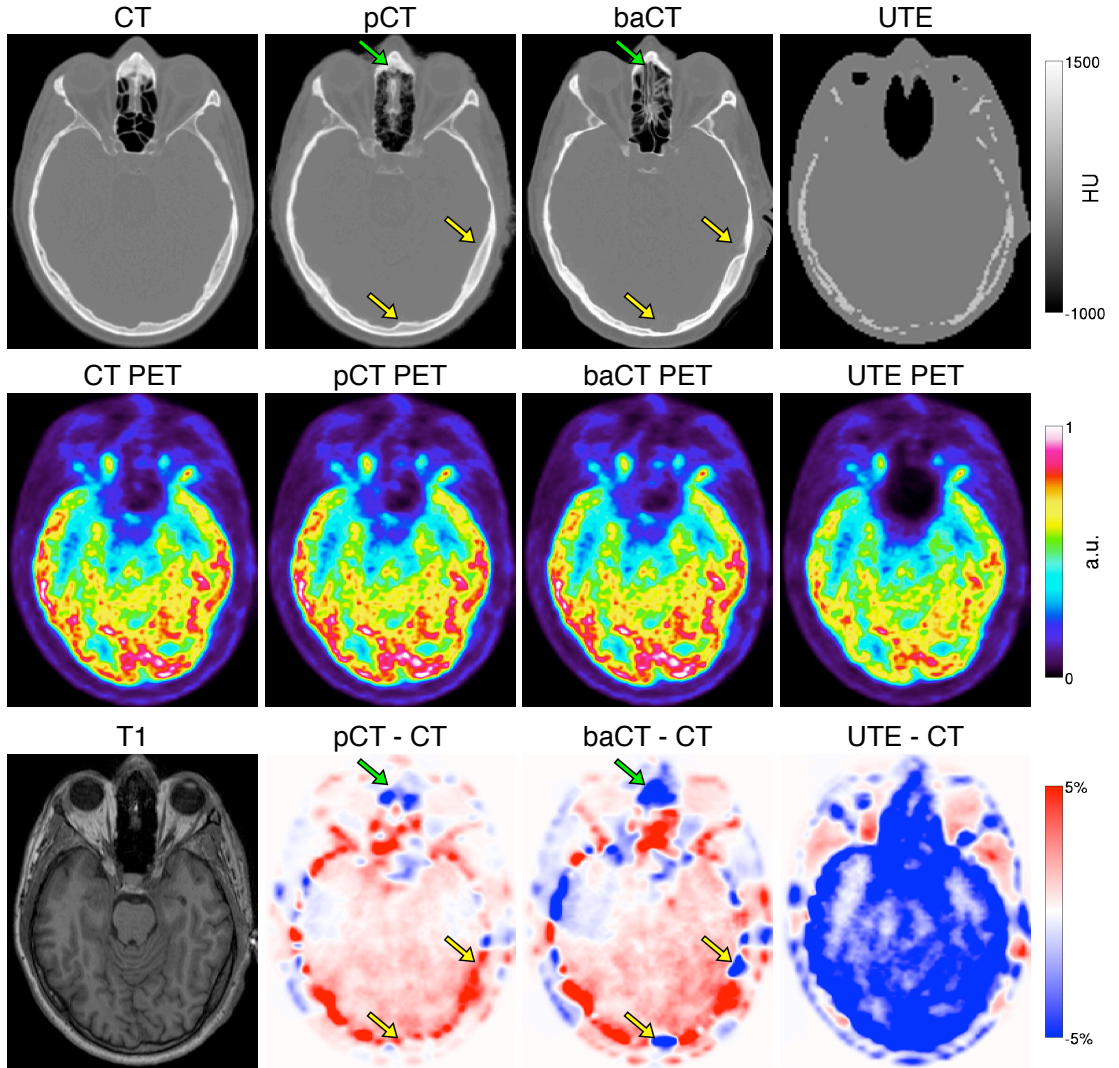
From left to right: The CT μ -map, the pCT μ -map generated by the proposed method, the baCT μ map and the UTE μ -map (top row). The reference FDG PET, pCT PET, baCT PET and UTE PET reconstructed with the off-line Siemens Healthcare software (middle row). The T1, the difference between the pCT and CT PETs, the baCT and CT PETs and the UTE and CT PETs (bottom row).
